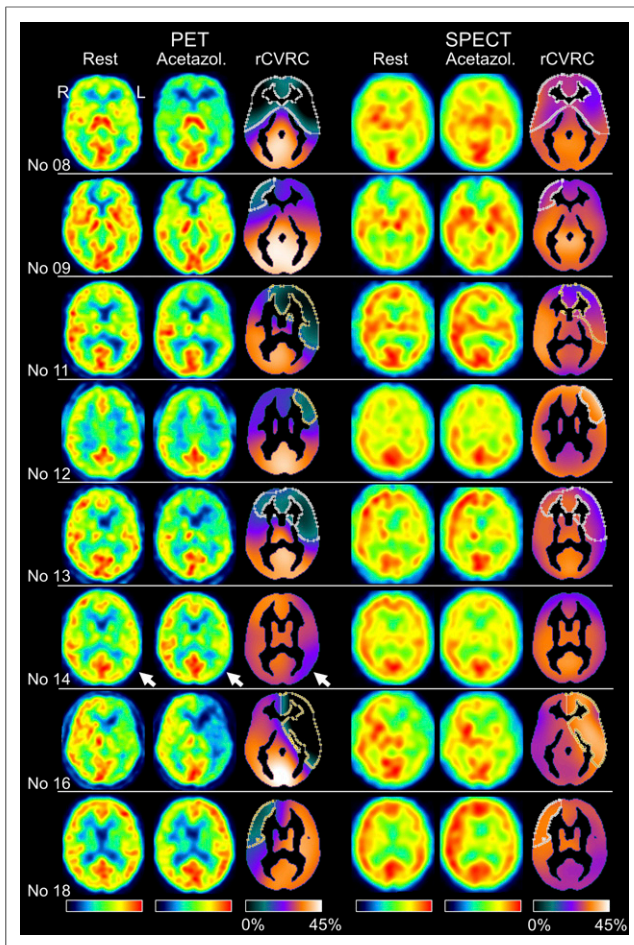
Patients with impaired CVRC according to visual interpretation of ^{15}O -water PET despite “no evidence of impaired CVRC” in the $^{99\text{m}}\text{Tc}$ -HMPAO SPECT images. Columns 1 to 3 show representative transversal slice of ^{15}O -water PET at rest and under acetazolamide challenge together with rCVRC map. Contour in rCVRC map delineates CVRC defect obtained by thresholding rCVRC map at 15% (i.e., 50% reduction from normal rCVRC set to 30%). CVRC reduction in left temporooccipital cortex in patient 14 (arrows) did not reach this threshold. Columns 4 to 6 show same slice in $^{99\text{m}}\text{Tc}$ -HMPAO SPECT images. Contour in SPECT CVRC map is copy of contour from PET CVRC map.
